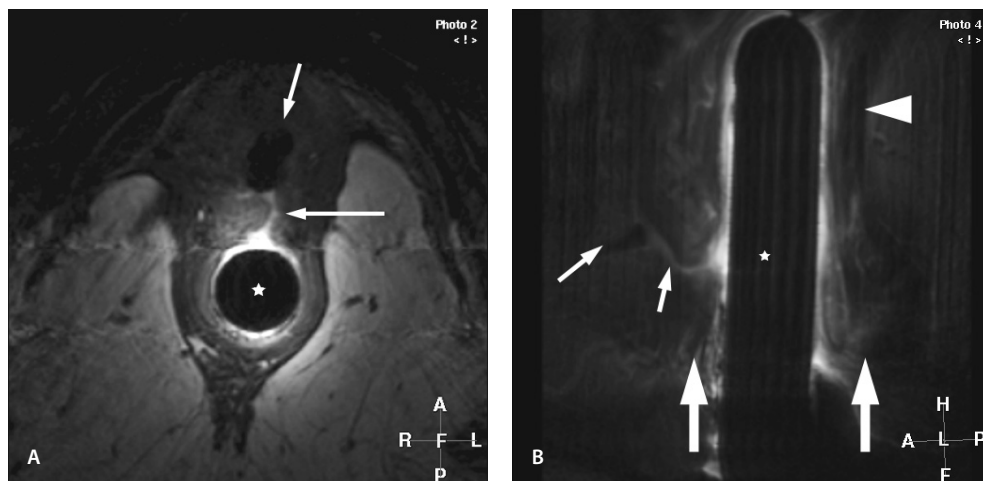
Simple anovaginal fistula. (a) Transverse T2-weighted fast Spin Echo (SE) MR image (2,500/100) shows an anovaginal fistula (straight arrow) as a high signal intensity linear abnormality, with direct depiction of the internal openings with the anal canal containing the endoanal coil (★) and the vagina containing some air (upper arrow). (b) Sagittal T2-weighted fast SE MR image (2,443/100) confirms the findings of transverse MR imaging and shows the relationship of the anovaginal fistula (thin straight arrow) to the lower edge of the anal sphincter complex (thick straight arrows) that clinically indicates the position of the anal verge. The vagina (left arrow), puborectal muscle (arrowhead), and endoanal coil (★) are also shown.
